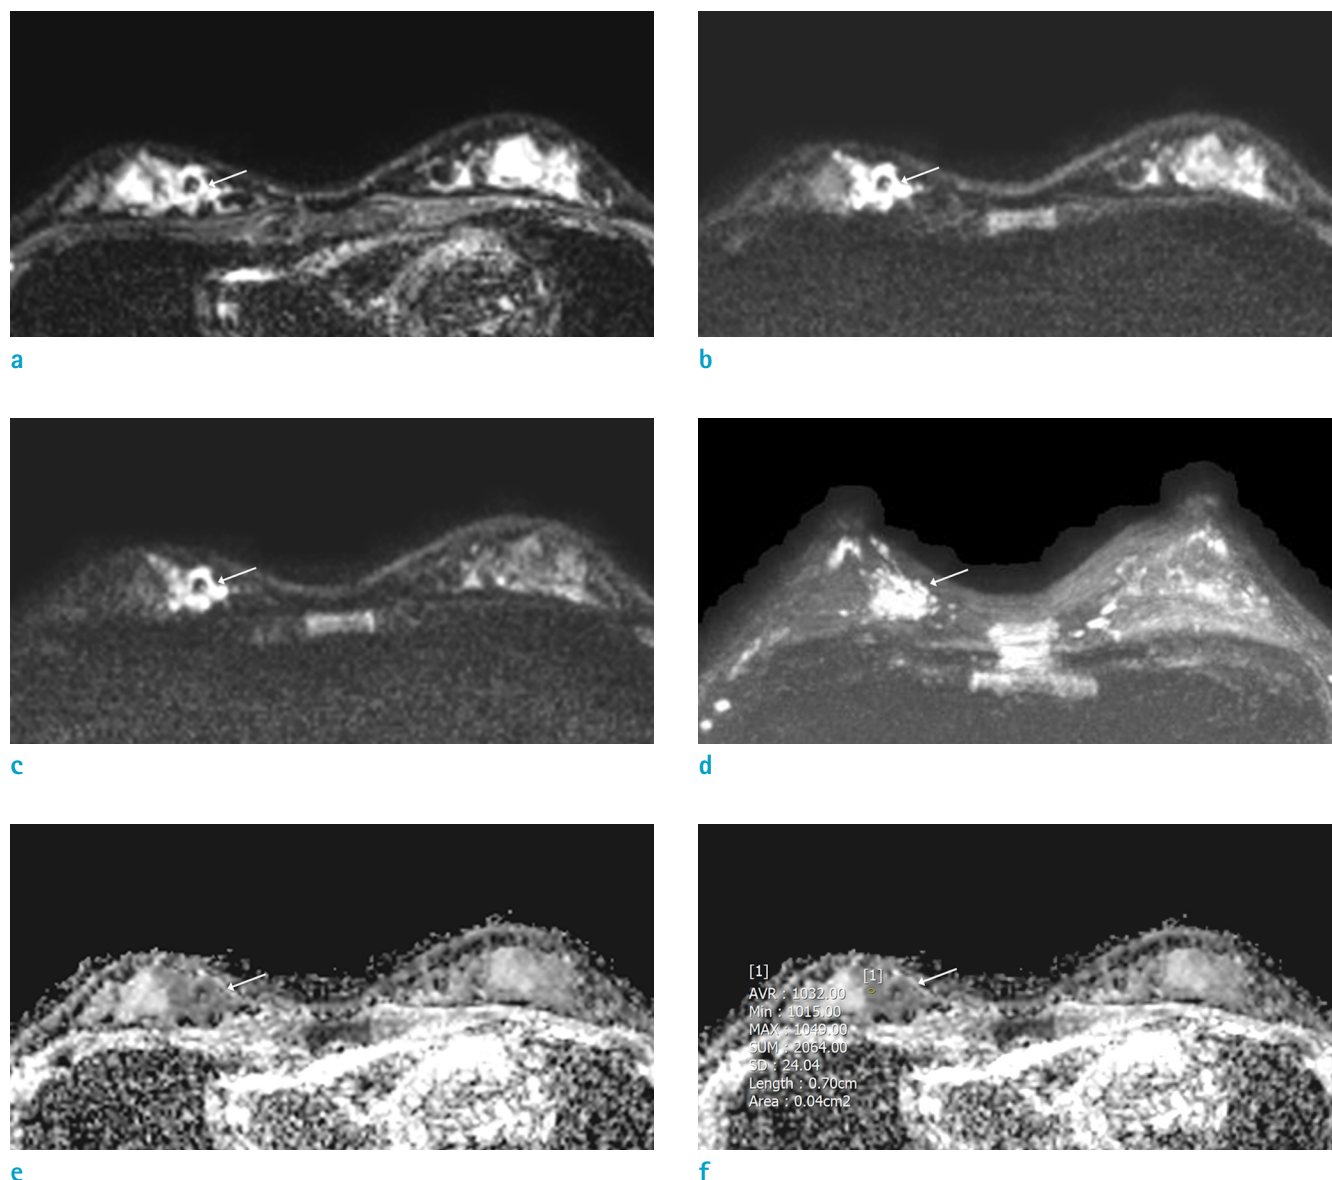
A 31-year-old woman with DCIS underwent breast diffusion-weighted MRI for screening for high risk, based on family and personal history (previous excision for intraductal papilloma, atypical ductal hyperplasia, flat epithelial atypia). (a–d) On diffusion-weighted images with b values of (a) 0, (b) 800, and (c) 1200 s/min² and (d) a maximal intensity projection image, there was a 2.9 × 2.7 × 6.2 cm (anteroposterior × transverse × craniocaudal), regional, heterogeneous, high SI nonmass (arrows) at the middle portion (distance from nipple: 1.2 cm) in the 3 o'clock direction of the right breast. (e, f) The apparent diffusion coefficient values of the apparent diffusion coefficient map were low (1.0 × 10⁻³ mm²/s) (arrows).
